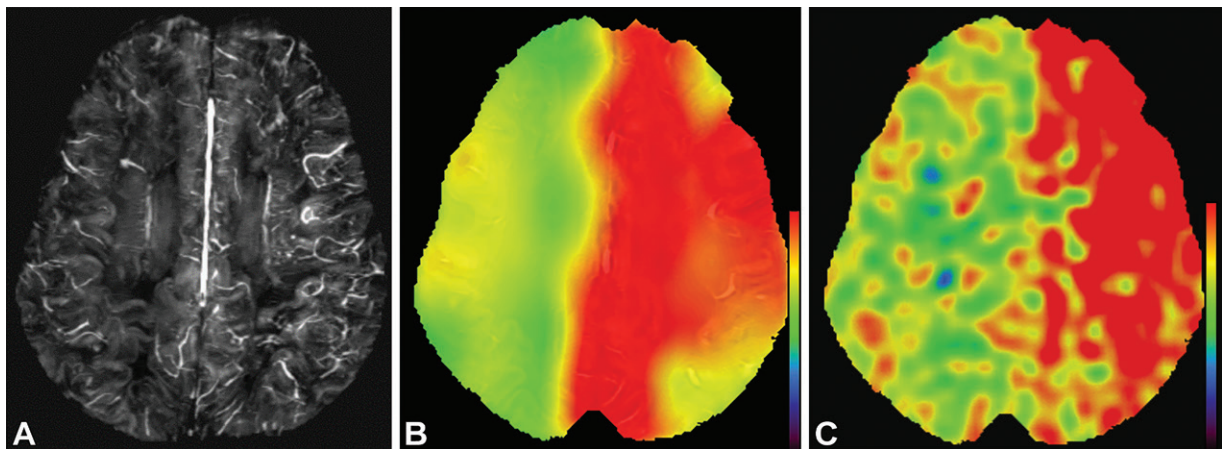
Left middle cerebral artery occlusion in a 74-year-old man. (A) Axial partial MIP image from QSM at 7-T MRI shows enhanced cortical veins in the left cerebral hemisphere compared with those on the contralateral side, suggesting increased deoxyhemoglobin levels. (B) Axial QSM-OEF map shows elevated OEF values in the left cerebral hemisphere. (C) Axial ^{15}O -water PET image also shows elevated OEF values in the left cerebral hemisphere.
